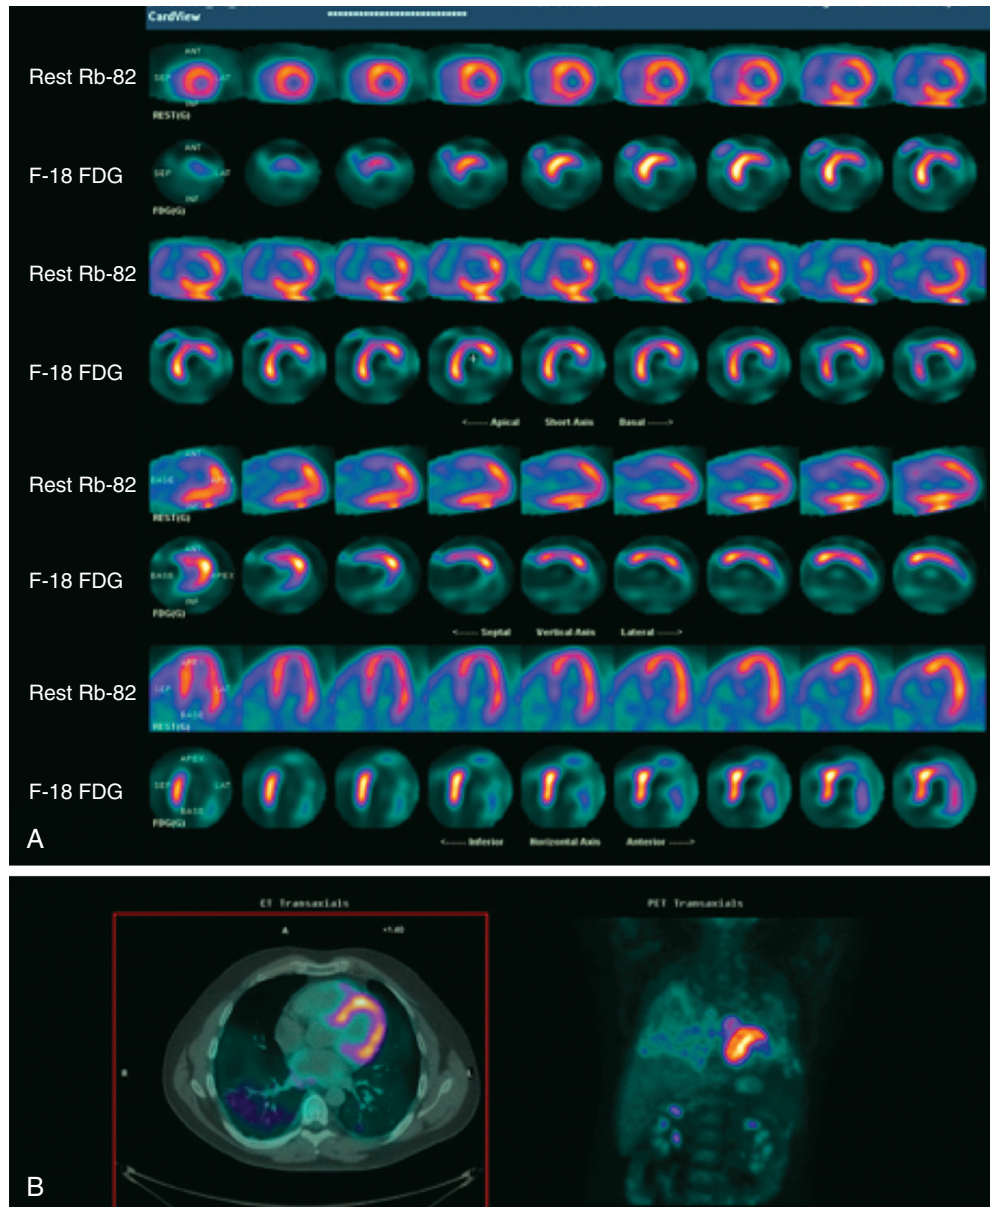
PET scan in a patient with sarcoidosis. A combined resting PET scan using rubidium-82 and ^{18}F -FDG (a glucose analogue) is shown for a 53-year-old man with a history of pulmonary sarcoidosis who had palpitations and atrial flutter. A, From the top, each pair of images represents the rubidium-82 scan and, underneath it, the corresponding ^{18}F -FDG image. The scans show a basal and midanteroseptal perfusion defect with intense FDG uptake in these regions suggestive of myocardial inflammation. Normal myocardium does not exhibit any FDG uptake because it is using free fatty acids. B, Combined CT-PET images in the same patient demonstrating the intense cardiac uptake. (Courtesy Dr. Sharmila Dorbala, Brigham and Women's Hospital, Boston. From Dubrey SW, Falk RH: *Diagnosis and management of cardiac sarcoidosis*. *Prog Cardiovasc Dis* 52:336, 2010.)
